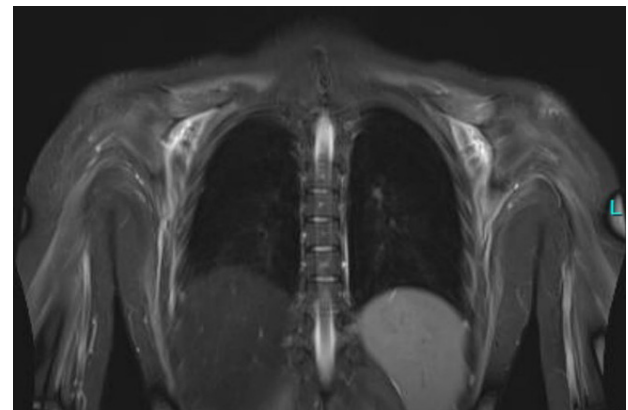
Magnetic resonance imaging of the upper torso and upper extremities in the same patient as in *Figure 1* showing diffuse myositis.
